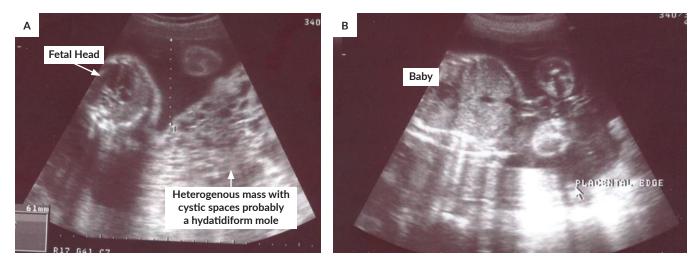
Ultrasound picture of Case 1. (A) Shows the proximity of the fetus to the molar mass; (B) Shows the placental edge of the normal fetus.
